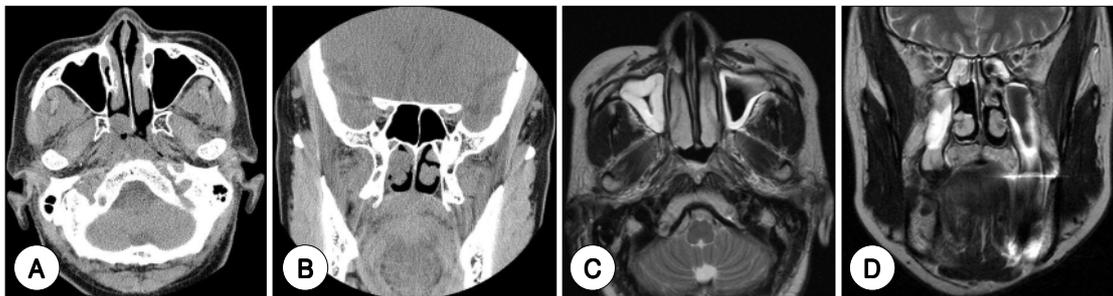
Images of case 2. Axial (A) and coronal (B) CT images show round mass originated from lateral nasal wall near the posterior end of middle turbinate. There is no evidence of residual or recurrent tumor on axial (C) and coronal (D) T2 MRI images after 25 months.
